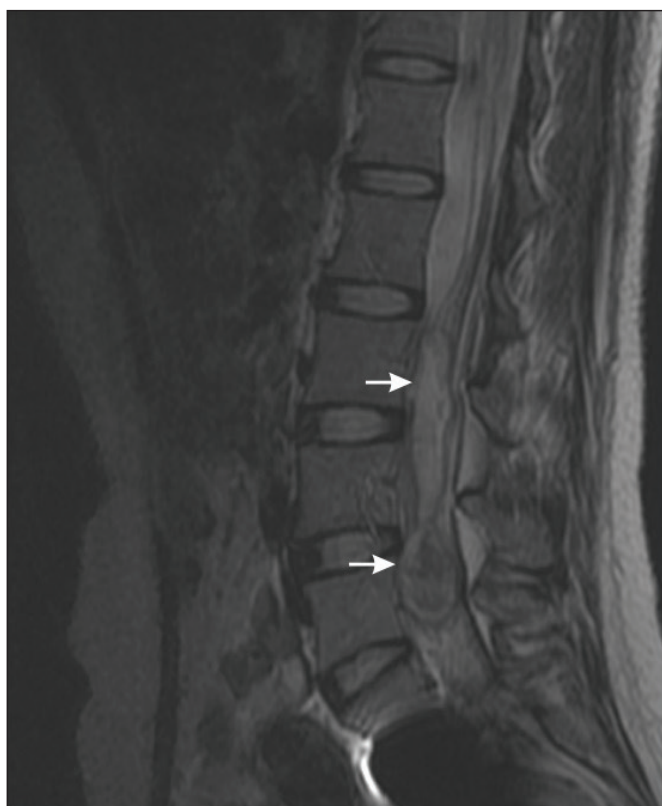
Spinal tapeworm. T2-weighted MR image of intradural-extramedullary lesion (arrows).
